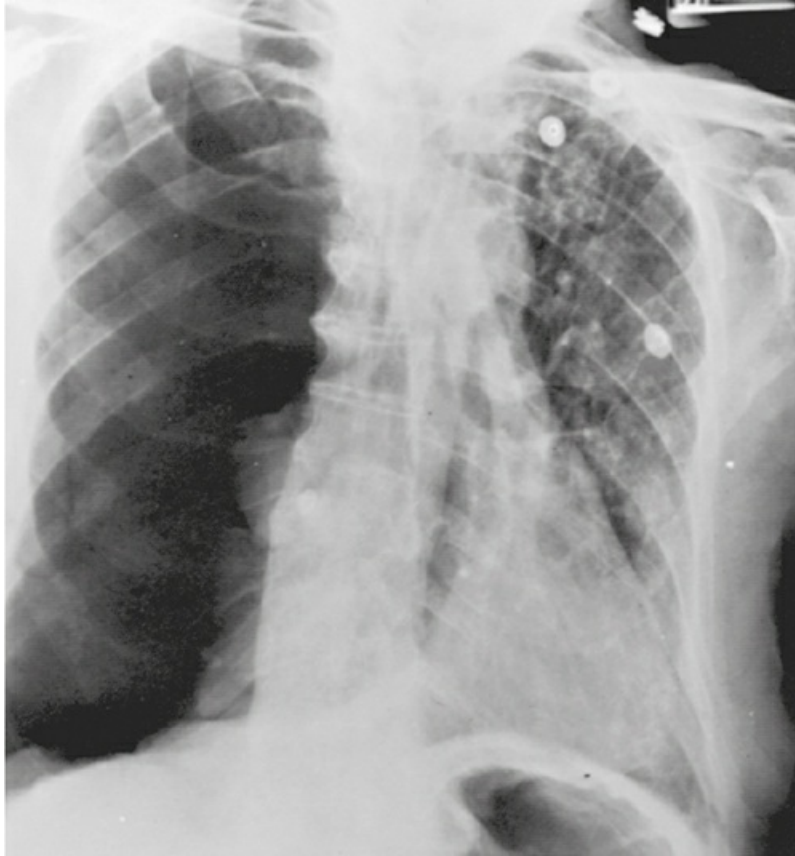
Chest radiograph shows right-sided tension pneumothorax. No lung markings are seen in right hemithorax, and mediastinum is shifted to left.
